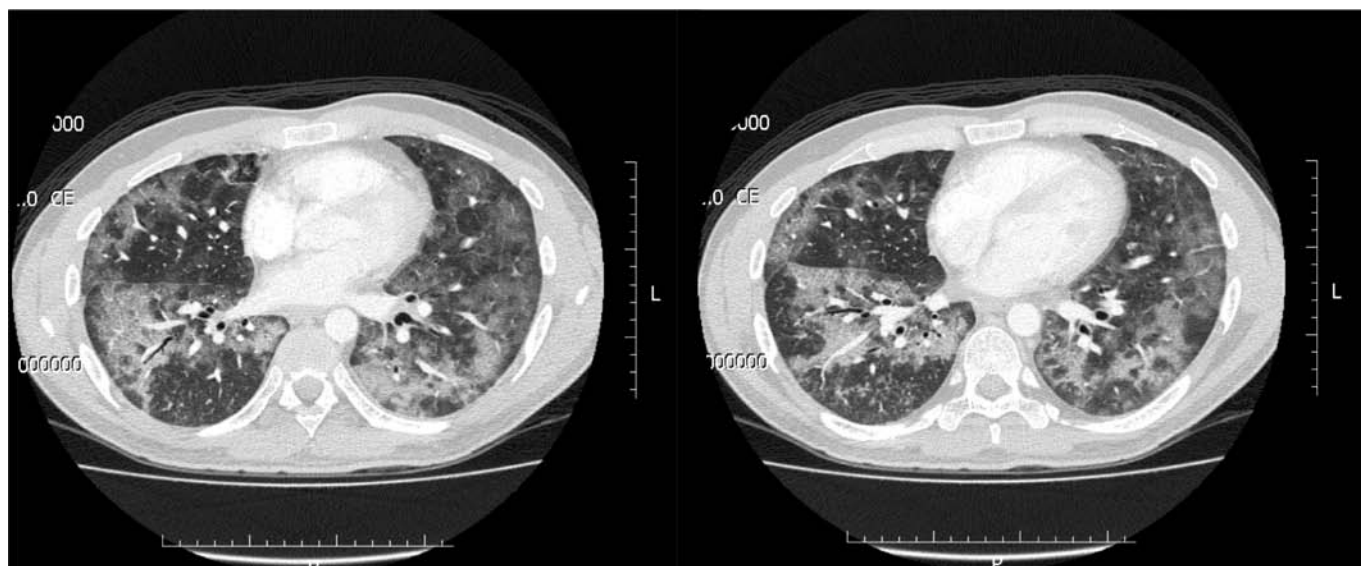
Thoracic computed tomography at admission. Extensive opacities with a predominantly "ground glass" appearance and bilateral diffuse involvement.
